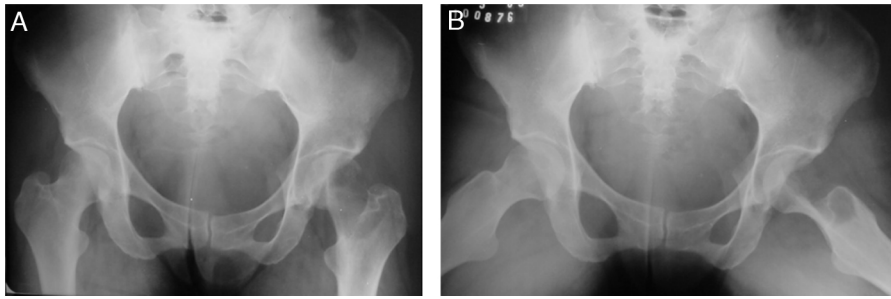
Hip radiograph in anteroposterior (A) and Lowenstein lateral (B) views showing osteolytic lesion in the left femoral neck.
